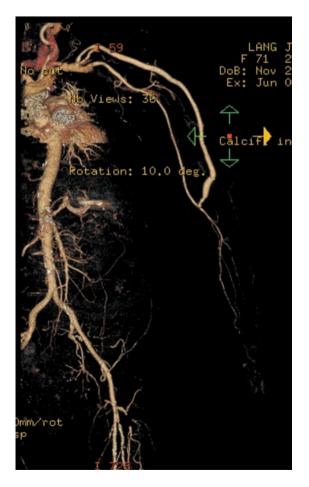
High-quality CTA showing the entire arterial tree
